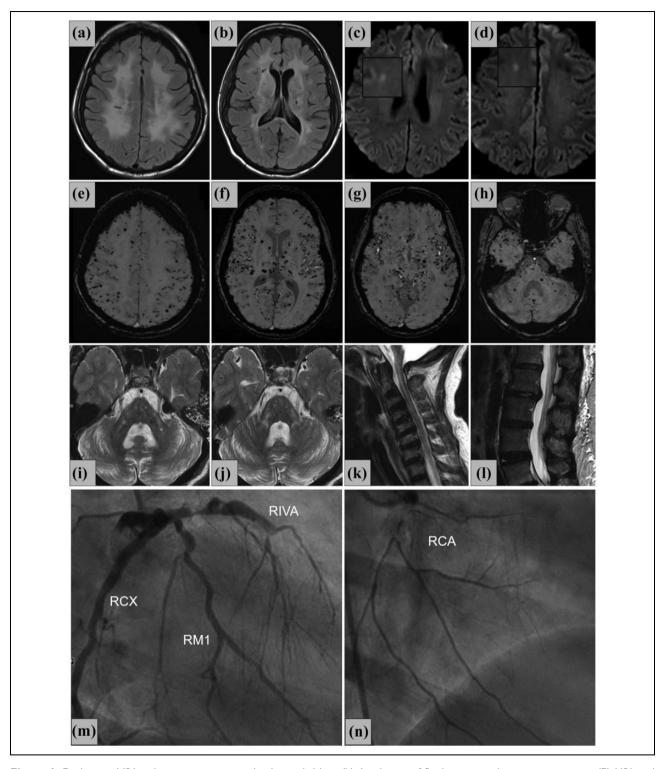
Findings in MRI and coronary angiography. Legend: (a) to (b) Axial view of fluid-attenuated inversion recovery (FLAIR) and conventional T2-weighted images; (c) to (d) axial view of diffusion-weighted images (DWI); (e) to (h) axial view of susceptibility-weighted imaging (SWI); (i) to (j) T2; (k) to (l) sagittal view of T2-weighted images, cervical and lumbar spine. (m) to (n) Coronary angiography: right anterior oblique (RAO)-projection. Findings: (a) to (b) White matter hyperintensity; (c) to (d) focusing/zooming on acute microinfarction of the right frontal white matter; (e) to (h) distinct cerebral microbleeds; (i) to (j) incomplete "Arc-Sign," arc-shaped lesions of the brainstem, pons, and cerebellum; (k) to (l) distinct degenerative changes, cervical spondylosis, and lumbar disc prolapse and bulgings. (m) to (n) Left-dominant coronary circulation. Stenosis of (m): ramus interventricularis anterior (RIVA) and (n) right coronary artery (RCA).
